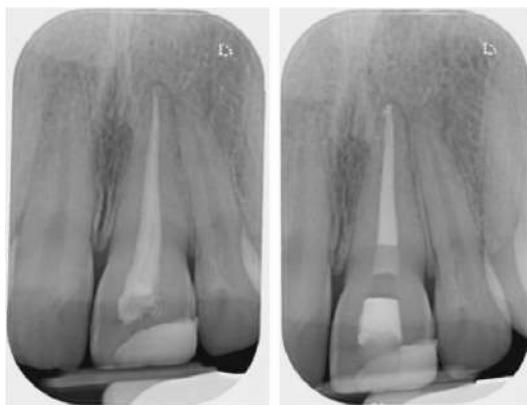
and Figure 2: Radiographs before and after re-root canal treatment
